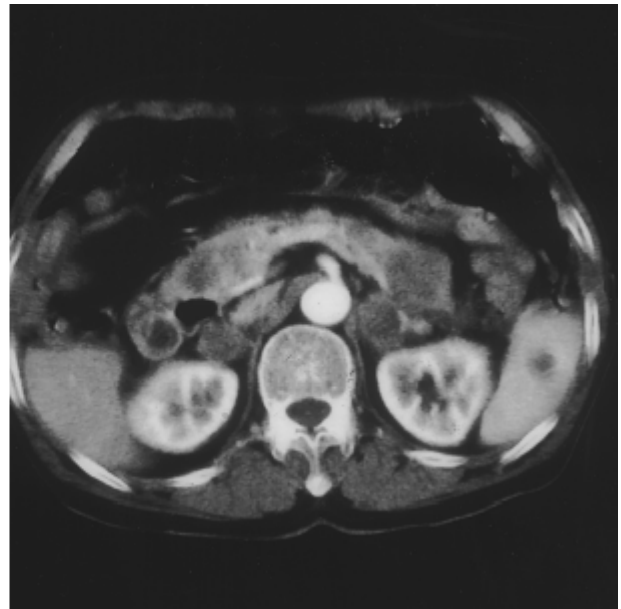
Computed tomography of the abdomen showed multiple low-attenuating metastatic masses within the swollen pancreas.
